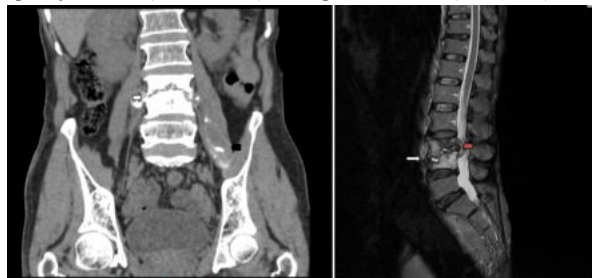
CT coronal reformatted image and MRI STIR Saggital image of Lumbar Spine of same patient showing L3-L4 Infective Spondylodiscitis (White arrow) with Epidural abscess (Red arrow) and calcifications in Left Psoas Abscess(Black arrow).
